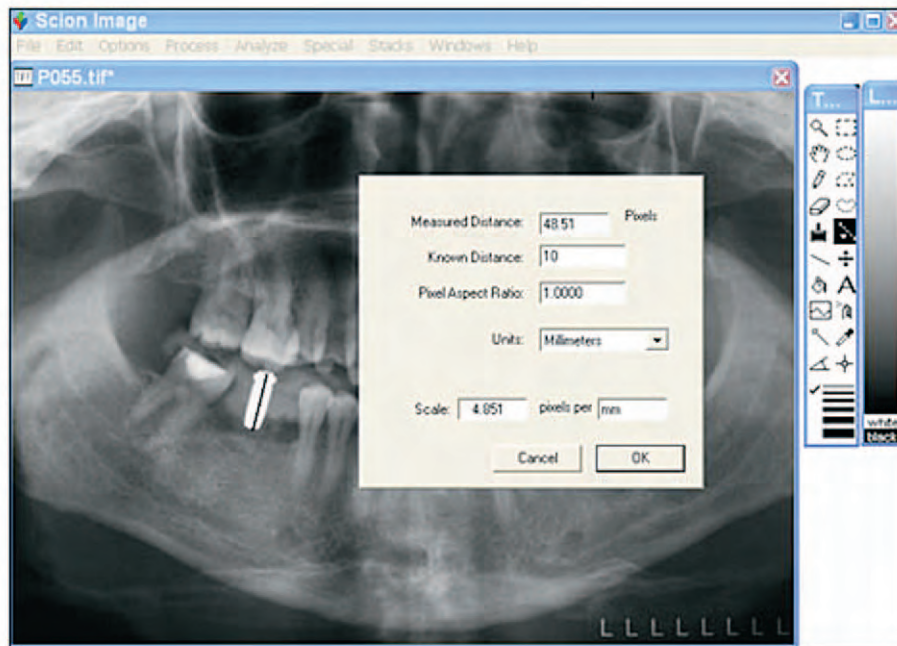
The radiograph loaded in Scion Image software with the calibration window showing the known measurement (10 mm to 48.51 pixels).
